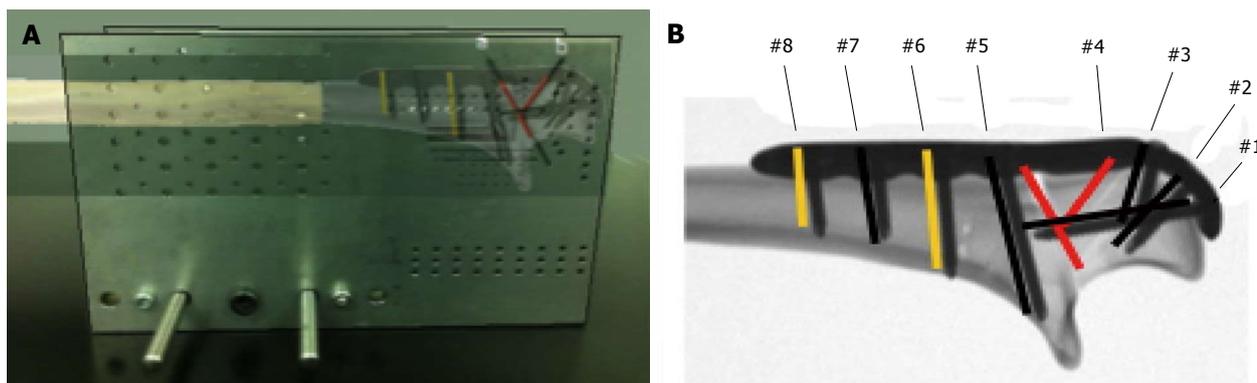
Custom osteotomy jig with plate and screw construct. A: Rendered photo of the jig used to create the comminuted olecranon fracture, with an overlay of the ulna, demonstrating the positioning of the bone in relation to the saw blade slots; B: A radiograph of the olecranon plate and screw construct in relation to the fracture. Screws placed in positions as indicated in Table 1.
